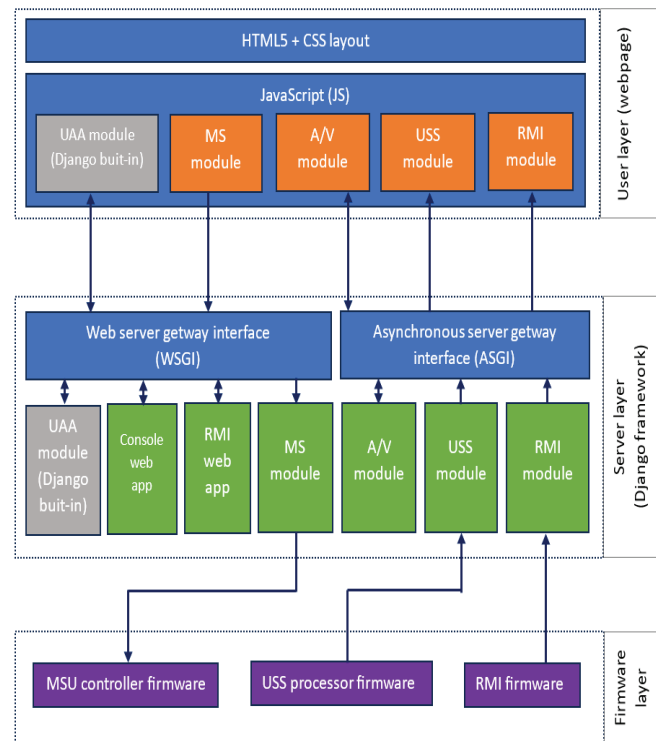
The robot software structure. Abbreviations: UAA: user authentication and authorisation; MS: movement and steering; A/V: audio and video; USS: ultrasonic sensor; RMI: radiation measurement interface; MSU: movement and steering unit. Arrows indicate connections and data flow.
